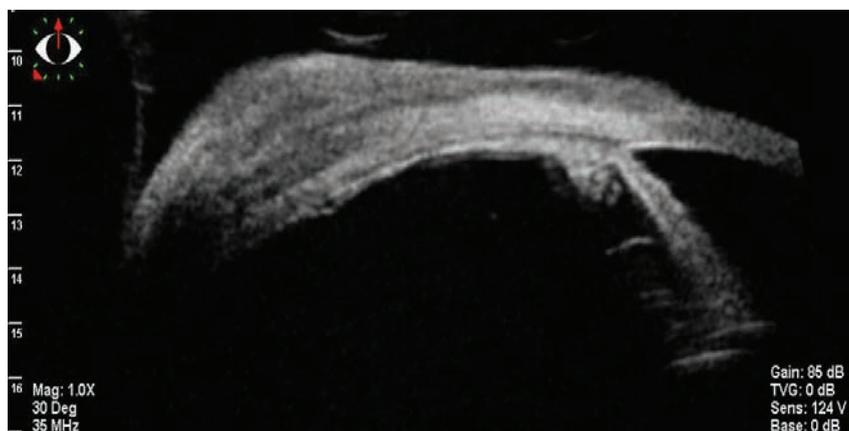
UBM ultrasonography of the scleromalacia of the left eye
